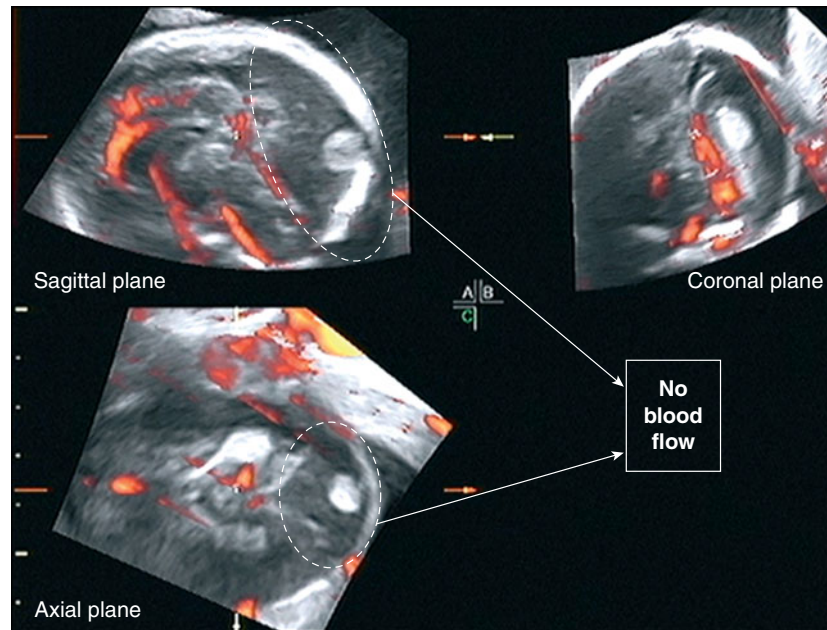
3D power Doppler image of a sinus thrombosis demonstrating the dilated sinus devoid of Doppler signals.
